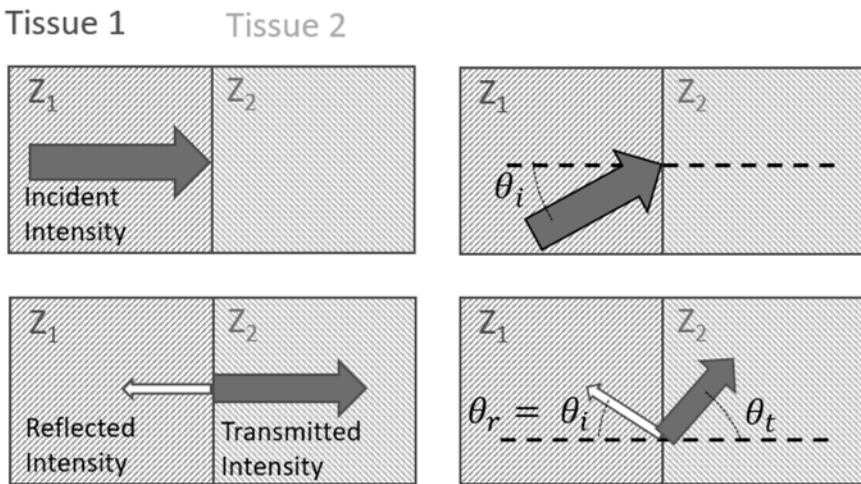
Intensity of the energy in an ultrasonic plane wave incident upon a smooth interface with dimensions much greater than that of the ultrasound wavelength will be partially reflected and partially transmitted according to equations [1.36] and [1.37] for perpendicular incidence, and according to equations [1.39] and [1.37] if the wave intersects the interface at an angle θ_i , with refraction of the transmitted wave according to equation [1.38]
